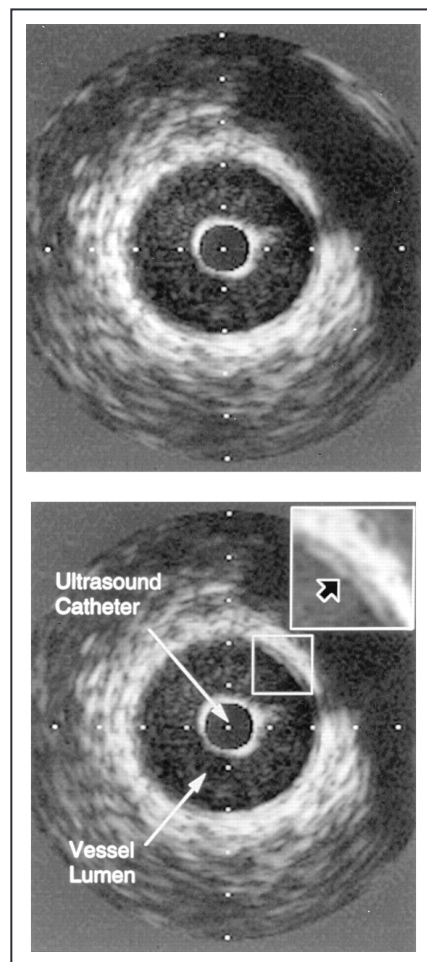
Ultrasound image of a normal coronary artery. Inset shows the three layers of the vessel wall (black arrow). The thin echogenic inner layer corresponds to the intima, the thin echolucent middle layer to the media, and the echogenic outer layer to the adventitia.
